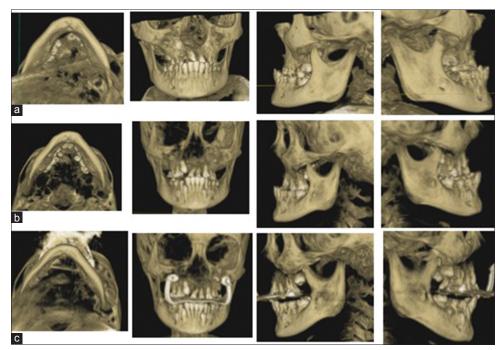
Cone-beam computed tomography images (a) predistraction. (b) Predistraction progress. (c) Postdistraction
